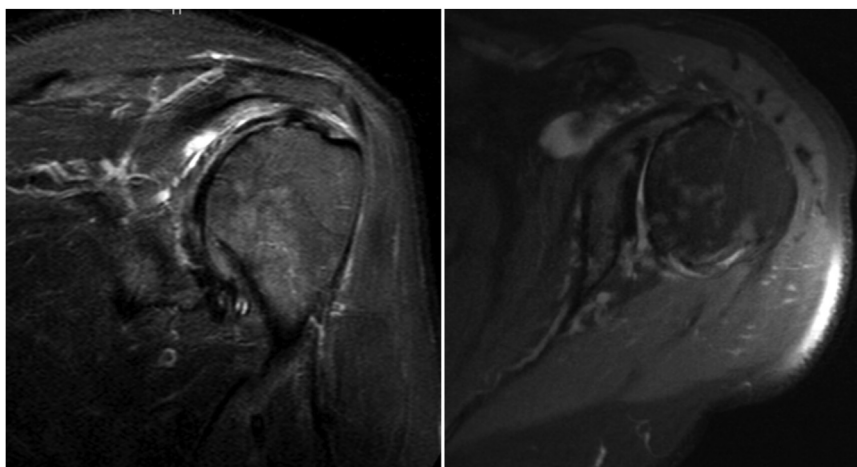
MRI of the left shoulder showing severe tendinosis of the supraspinatus. MRI, magnetic resonance imaging.
